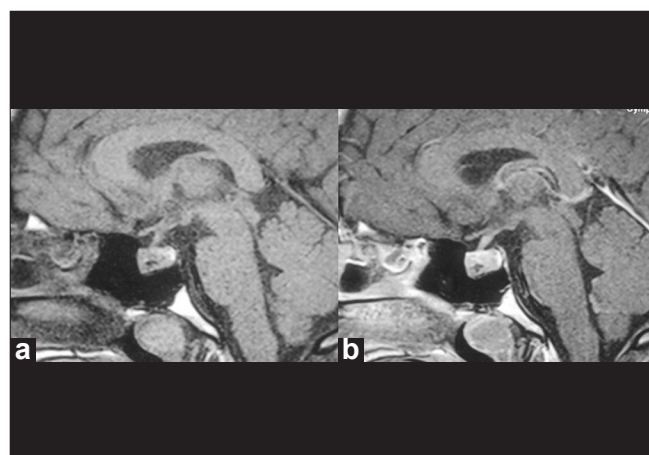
T1-weighted sagittal MRI image (a) shows a small hypointense area in the anterior pituitary which has the same appearance on post-contrast image (b)
